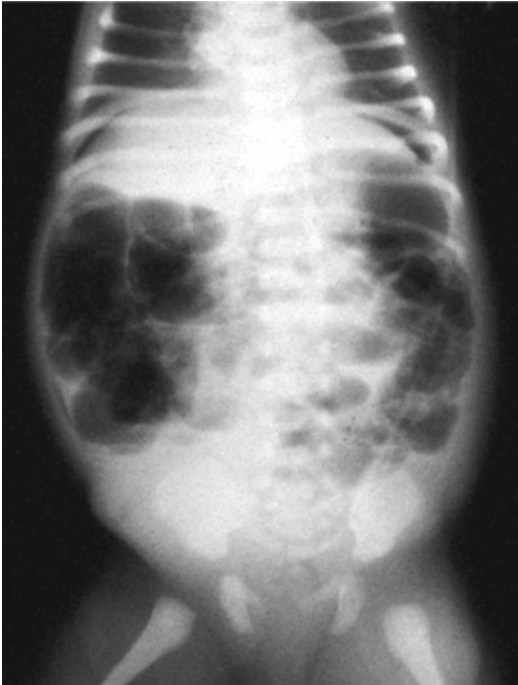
Abdominal plain film in newborn with NEC: pathological aspect of neonatal bowel, loss of “mosaic” aspect and focal distension of the loop
